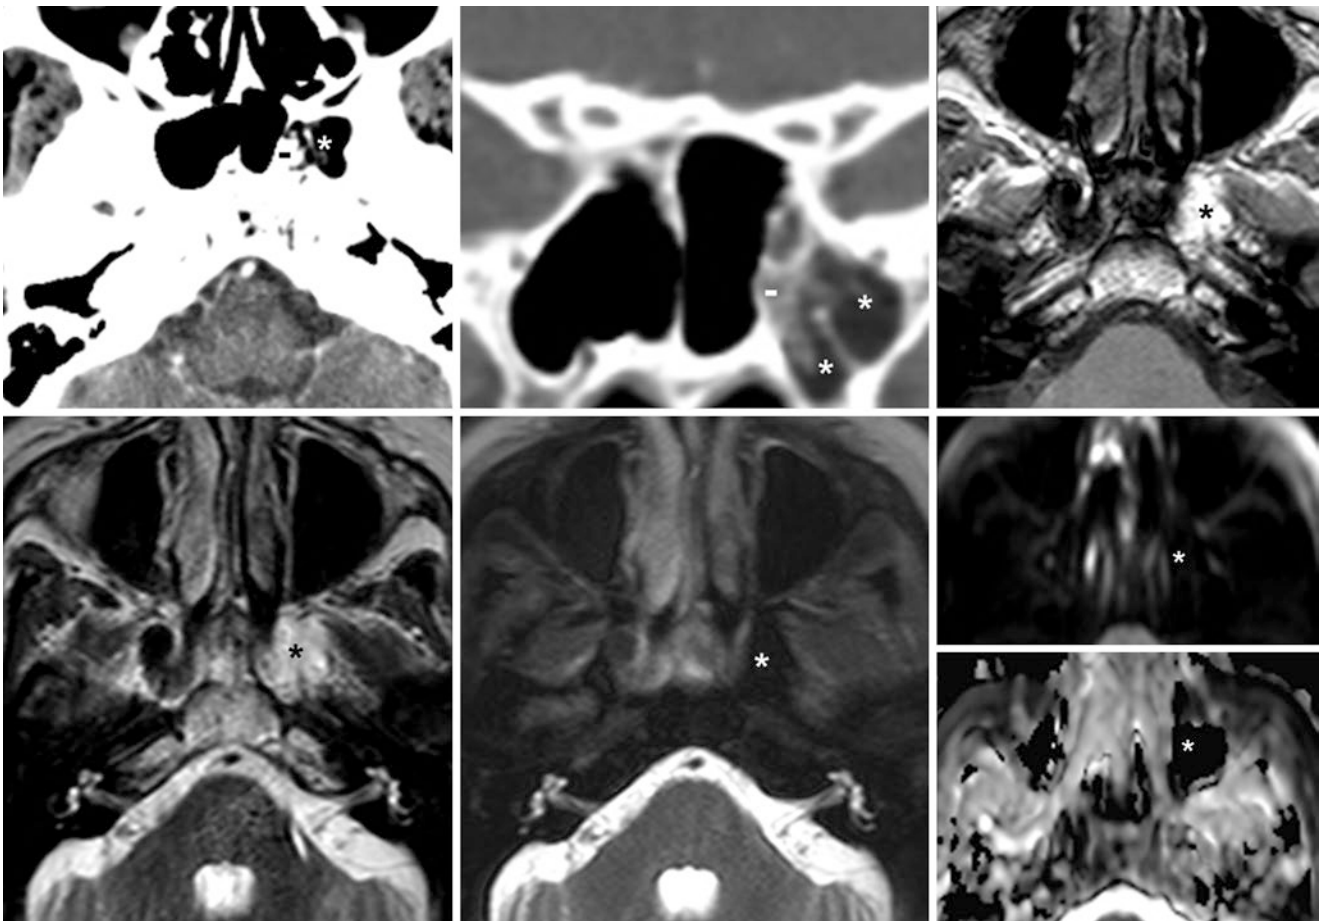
A 75 year old in whom on axial (*top left*) and coronal (*top middle*) CECT fat density (–60 HU) was noted (*asterisk*) within the sphenoid, which was ossified medially (*dash*). On 3T MRI, this was
